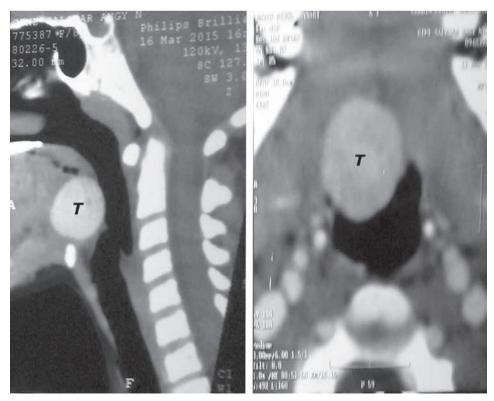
CT-scan demonstrating the presence of the mass at the base of the tongue, partially obstructing the digestive tract without compromising the airway.
